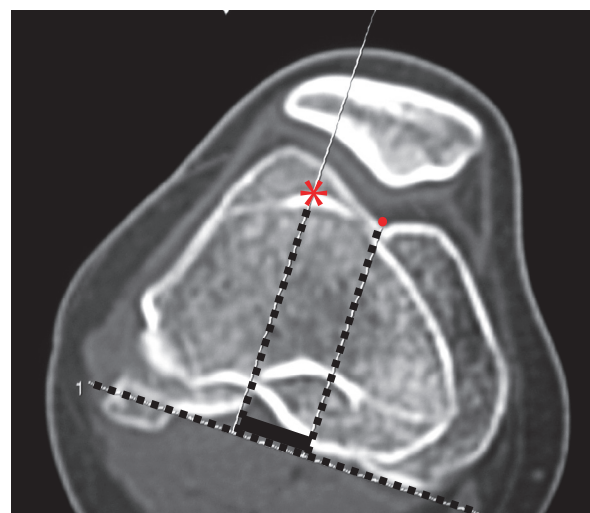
TT-TG distance measurements on axial CT scans
